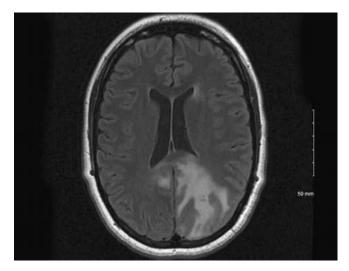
Cranial magnetic resonance imaging in a nullipara with eclampsia. This T2-FLAIR image shows an occipital lesion consistent with posterior reversible encephalopathy syndrome (PRES). FLAIR = fluid-attenuated inversion recovery.
